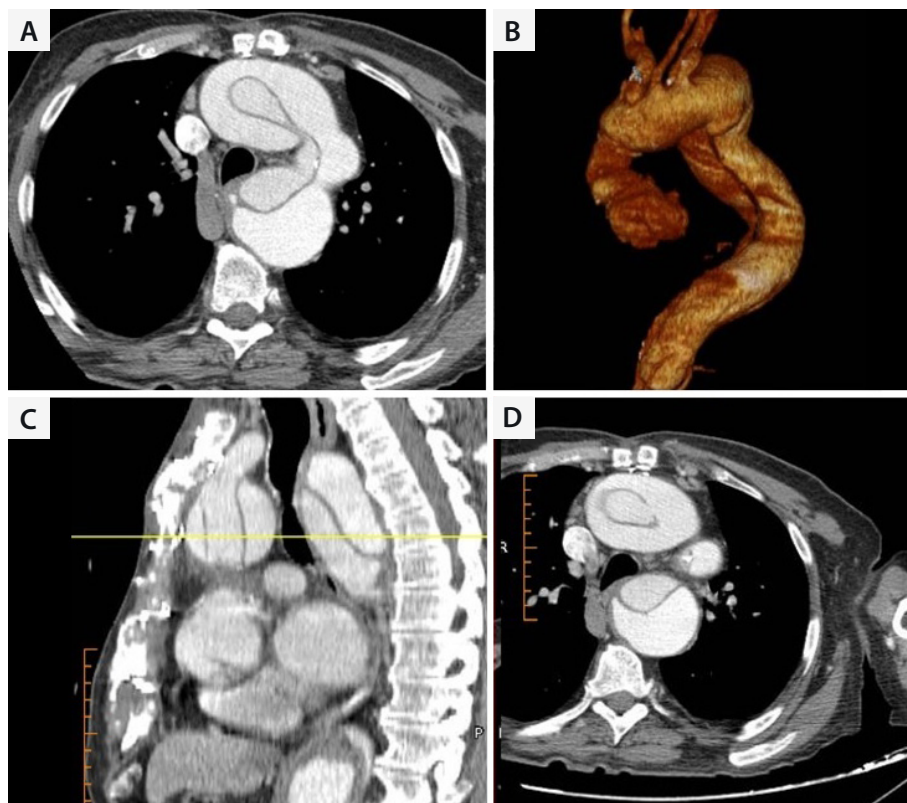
Preoperative computed tomography scan with reconstruction of the thoracic aorta showing the contact between the aneurismal ascending aorta and the sternum.
